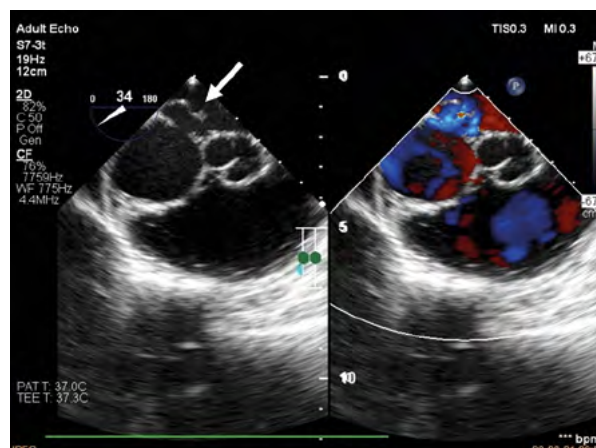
Transoesophageal echocardiography. In the left atrium normal and additional septum and free space between them (arrow)
